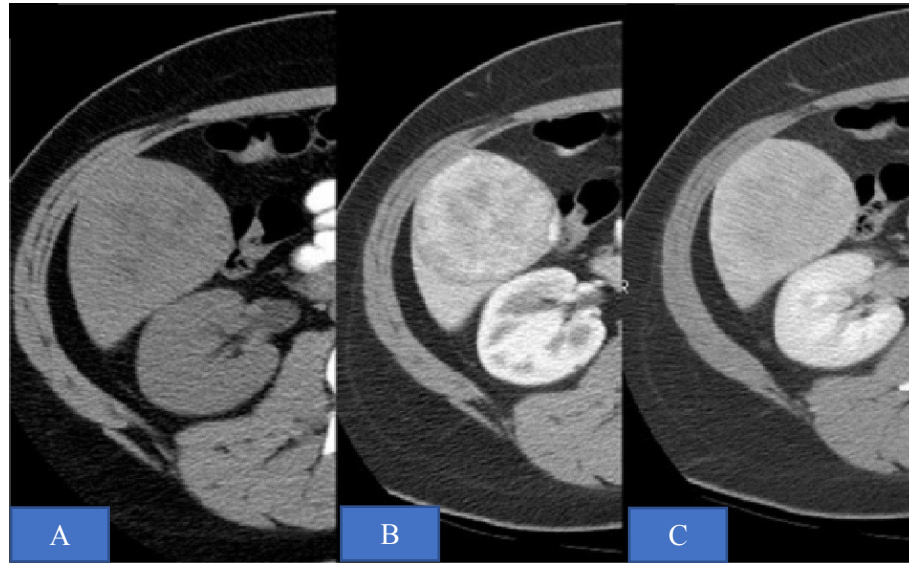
Hepatic adenoma. (A) Axial unenhanced CT scan shows a low-density hepatic mass with focal areas of fat. This lesion exhibits moderate, inhomogeneous contrast enhancement on hepatic arterial-phase image (B) that shows gradual washout on delayed phase (C).
